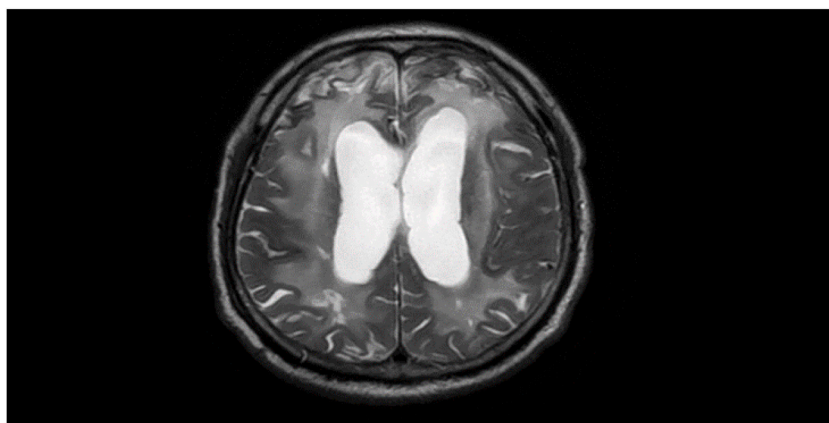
One picture of MRI.
